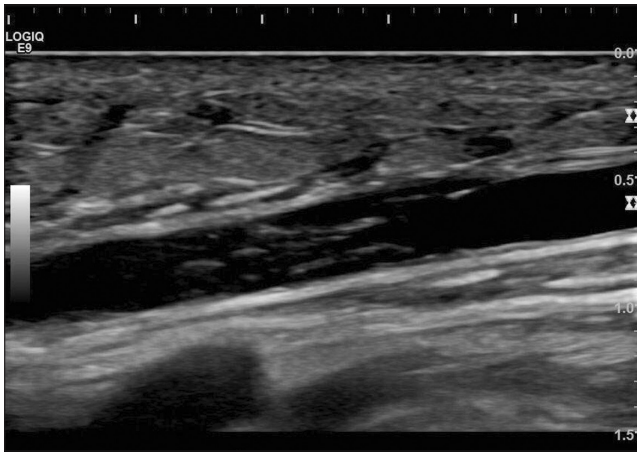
Duplex ultrasonographic images from a 53-year-old man who underwent arthroscopic repair for massive rotator cuff tear of right shoulder. Longitudinal image of the right cephalic vein shows a hypoechoic thrombus.
